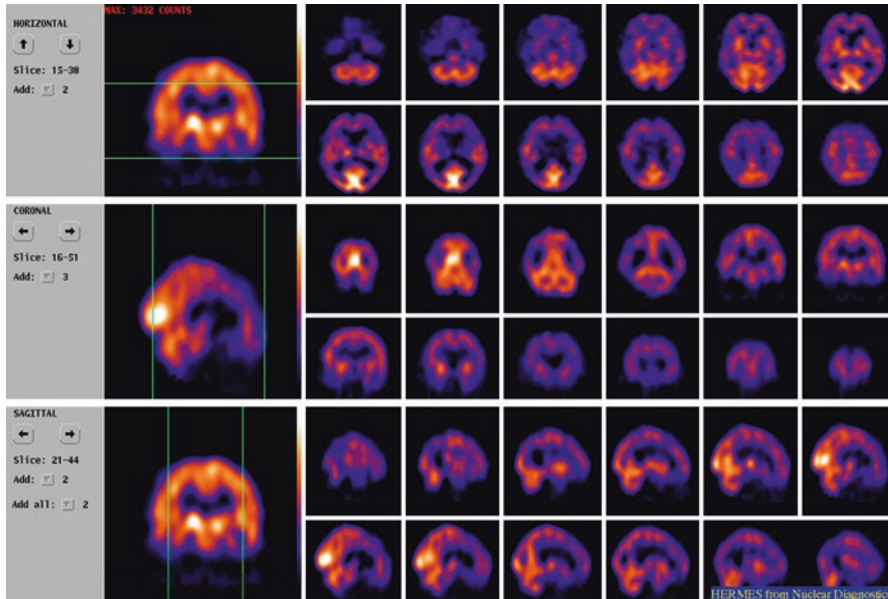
ECD SPECT on a triple-headed gamma camera of a patient suffering from advanced AD, respective transaxial, coronal and sagittal slices. Extended hypoperfusion, especially of the posterior cortical regions, but sparing sensorimotor and visual cortices, basal ganglia, thalamus, cerebellum and brainstem
